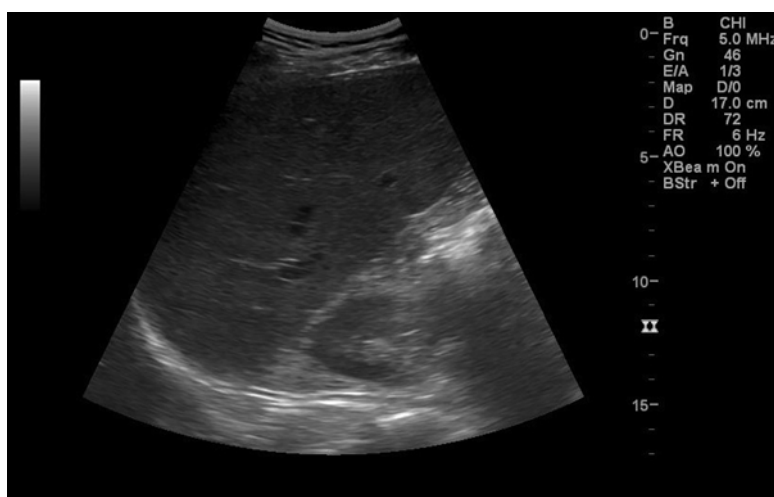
Showing ultrasound image obtained with one focal point at the level of interest. See *white arrow* indicating focus level indicator
